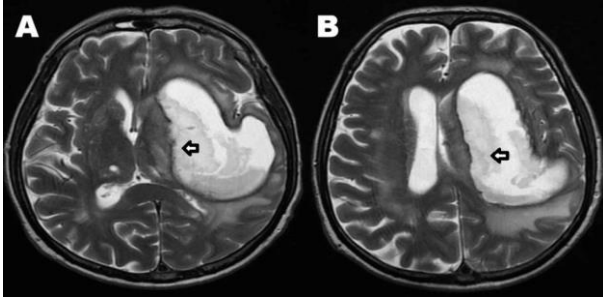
Follow-up CT scan showing an increase in hematoma size, extension into the left frontal and temporal lobes, and mass effect on the left lateral ventricle. Arrows indicating the expanding hematoma and accompanying midline shift.
